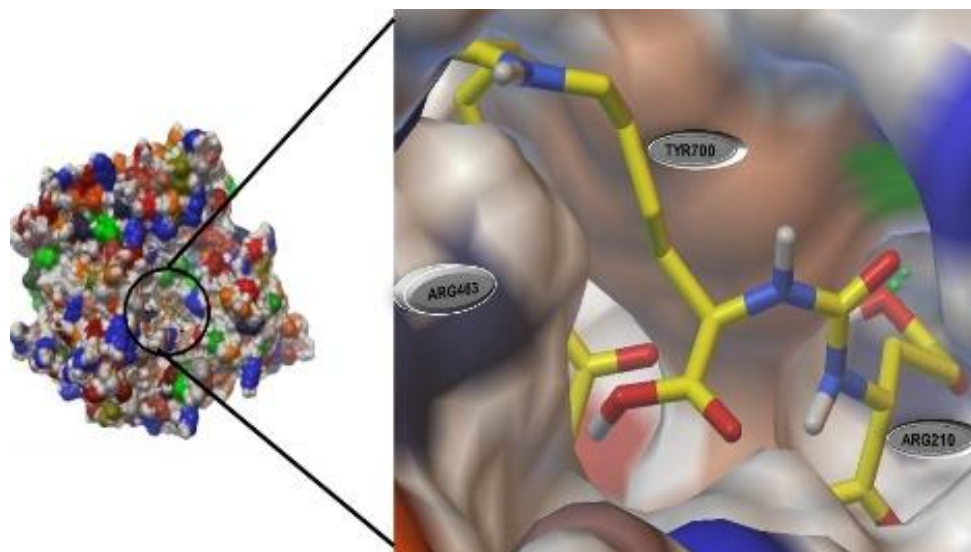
MMS view of PSMA precursor within the active pocket S1 of GCPII (PDB ID 2OOT)
